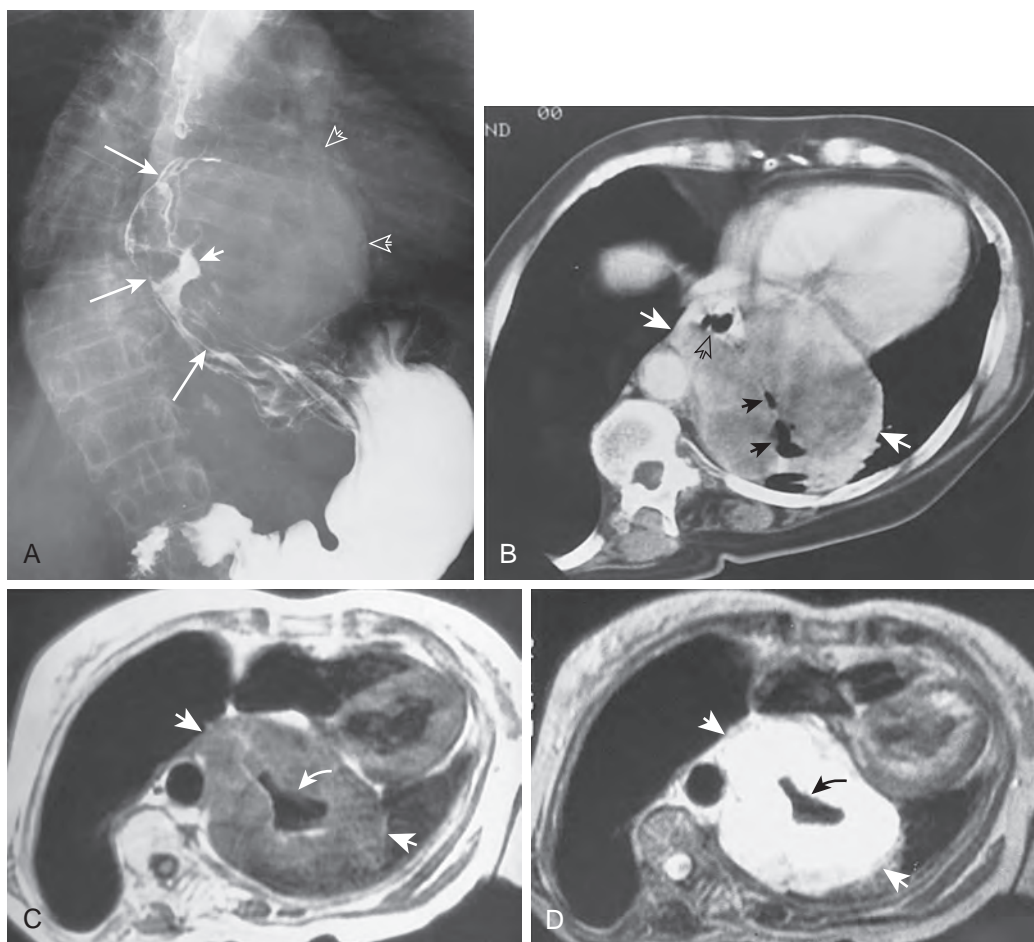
Esophageal leiomyosarcoma. A. Barium study shows a giant intramural mass (*large arrows*) with a bulky exophytic component in the mediastinum (*open arrows*). Note the relatively small central ulcer (*small arrow*) within the lesion. B. CT scan shows a heterogeneous mass (*white arrows*) in the left side of the mediastinum with central areas of low density. Note the extraluminal collections of gas (*solid black arrows*) within the lesion that are separate from the esophageal lumen (*open black arrow*). C. T1-weighted (TR/TE, 674/12) MRI scan also shows a mass (*straight arrows*) in the left side of the mediastinum. Note how the mass is isointense with skeletal muscle. D. T2-weighted (2697/80) MRI scan shows how the lesion (*straight arrows*) is markedly hyperintense relative to skeletal muscle. In both C and D, there is a focal area of signal void (*curved arrows*) caused by extraluminal gas within the tumor. (From Levine MS, Buck JL, Pantongrag-Brown L, et al: Leiomyosarcoma of the esophagus: Radiographic findings in 10 patients. *AJR* 167:27–32, 1996.)
